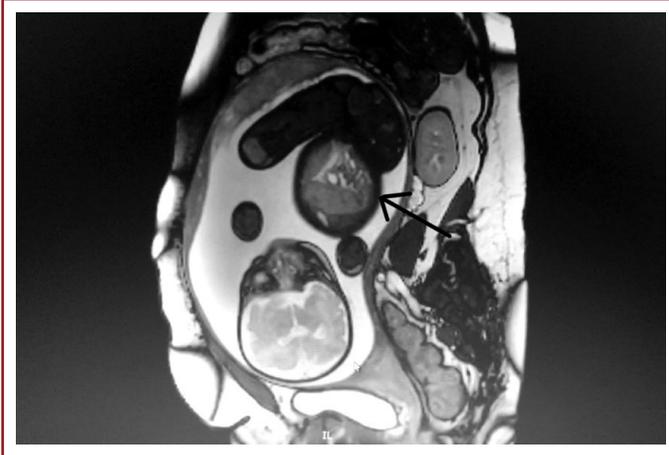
Fetal MRI, 60*52 mm mass appearance in left kidney (Area indicated by arrow: mass in fetal left kidney).
